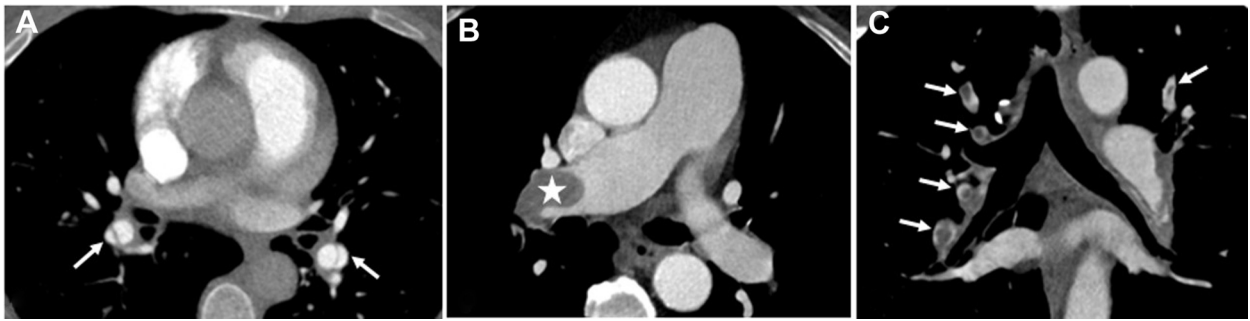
CT scan with contrast of different patients with evidence of pulmonary embolism. A, Axial image of patient with bilateral webs suggesting chronic thromboembolic pulmonary hypertension (white arrows). B, Axial image of patient with large pouch-like filling defect in the right main pulmonary artery (star). C, Coronal CT scan with multiple intraluminal filling defects in the segmental and subsegmental pulmonary arteries (white arrows).
